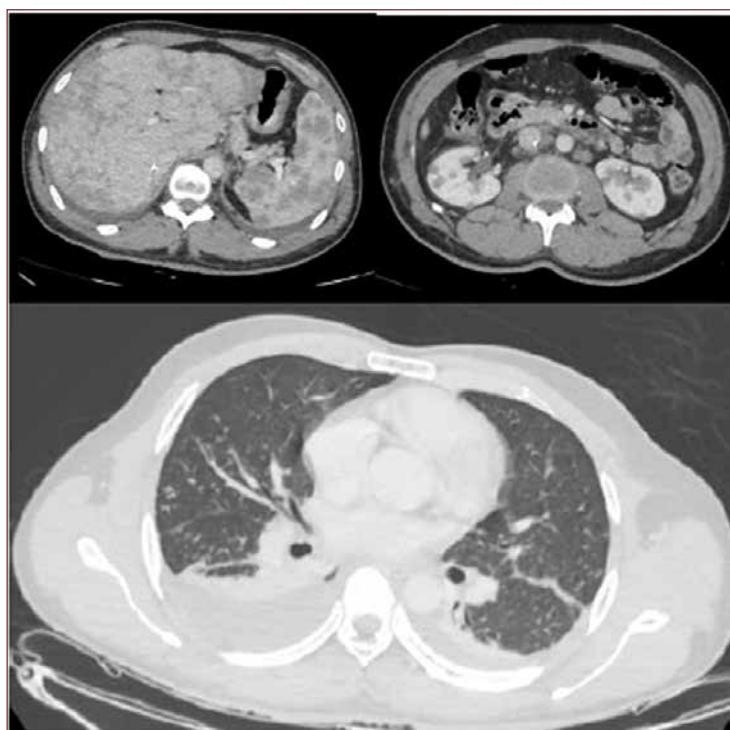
3 – CT Chest and abdomen- Sharply defined nodules with a predominantly peri lymphatic distribution in both lungs with mild pleural effusion. Tiny nodules and band like hypodense areas in the liver parenchyma. Splenomegaly with multiple parenchymal nodules and cortical nodules in both kidneys.
